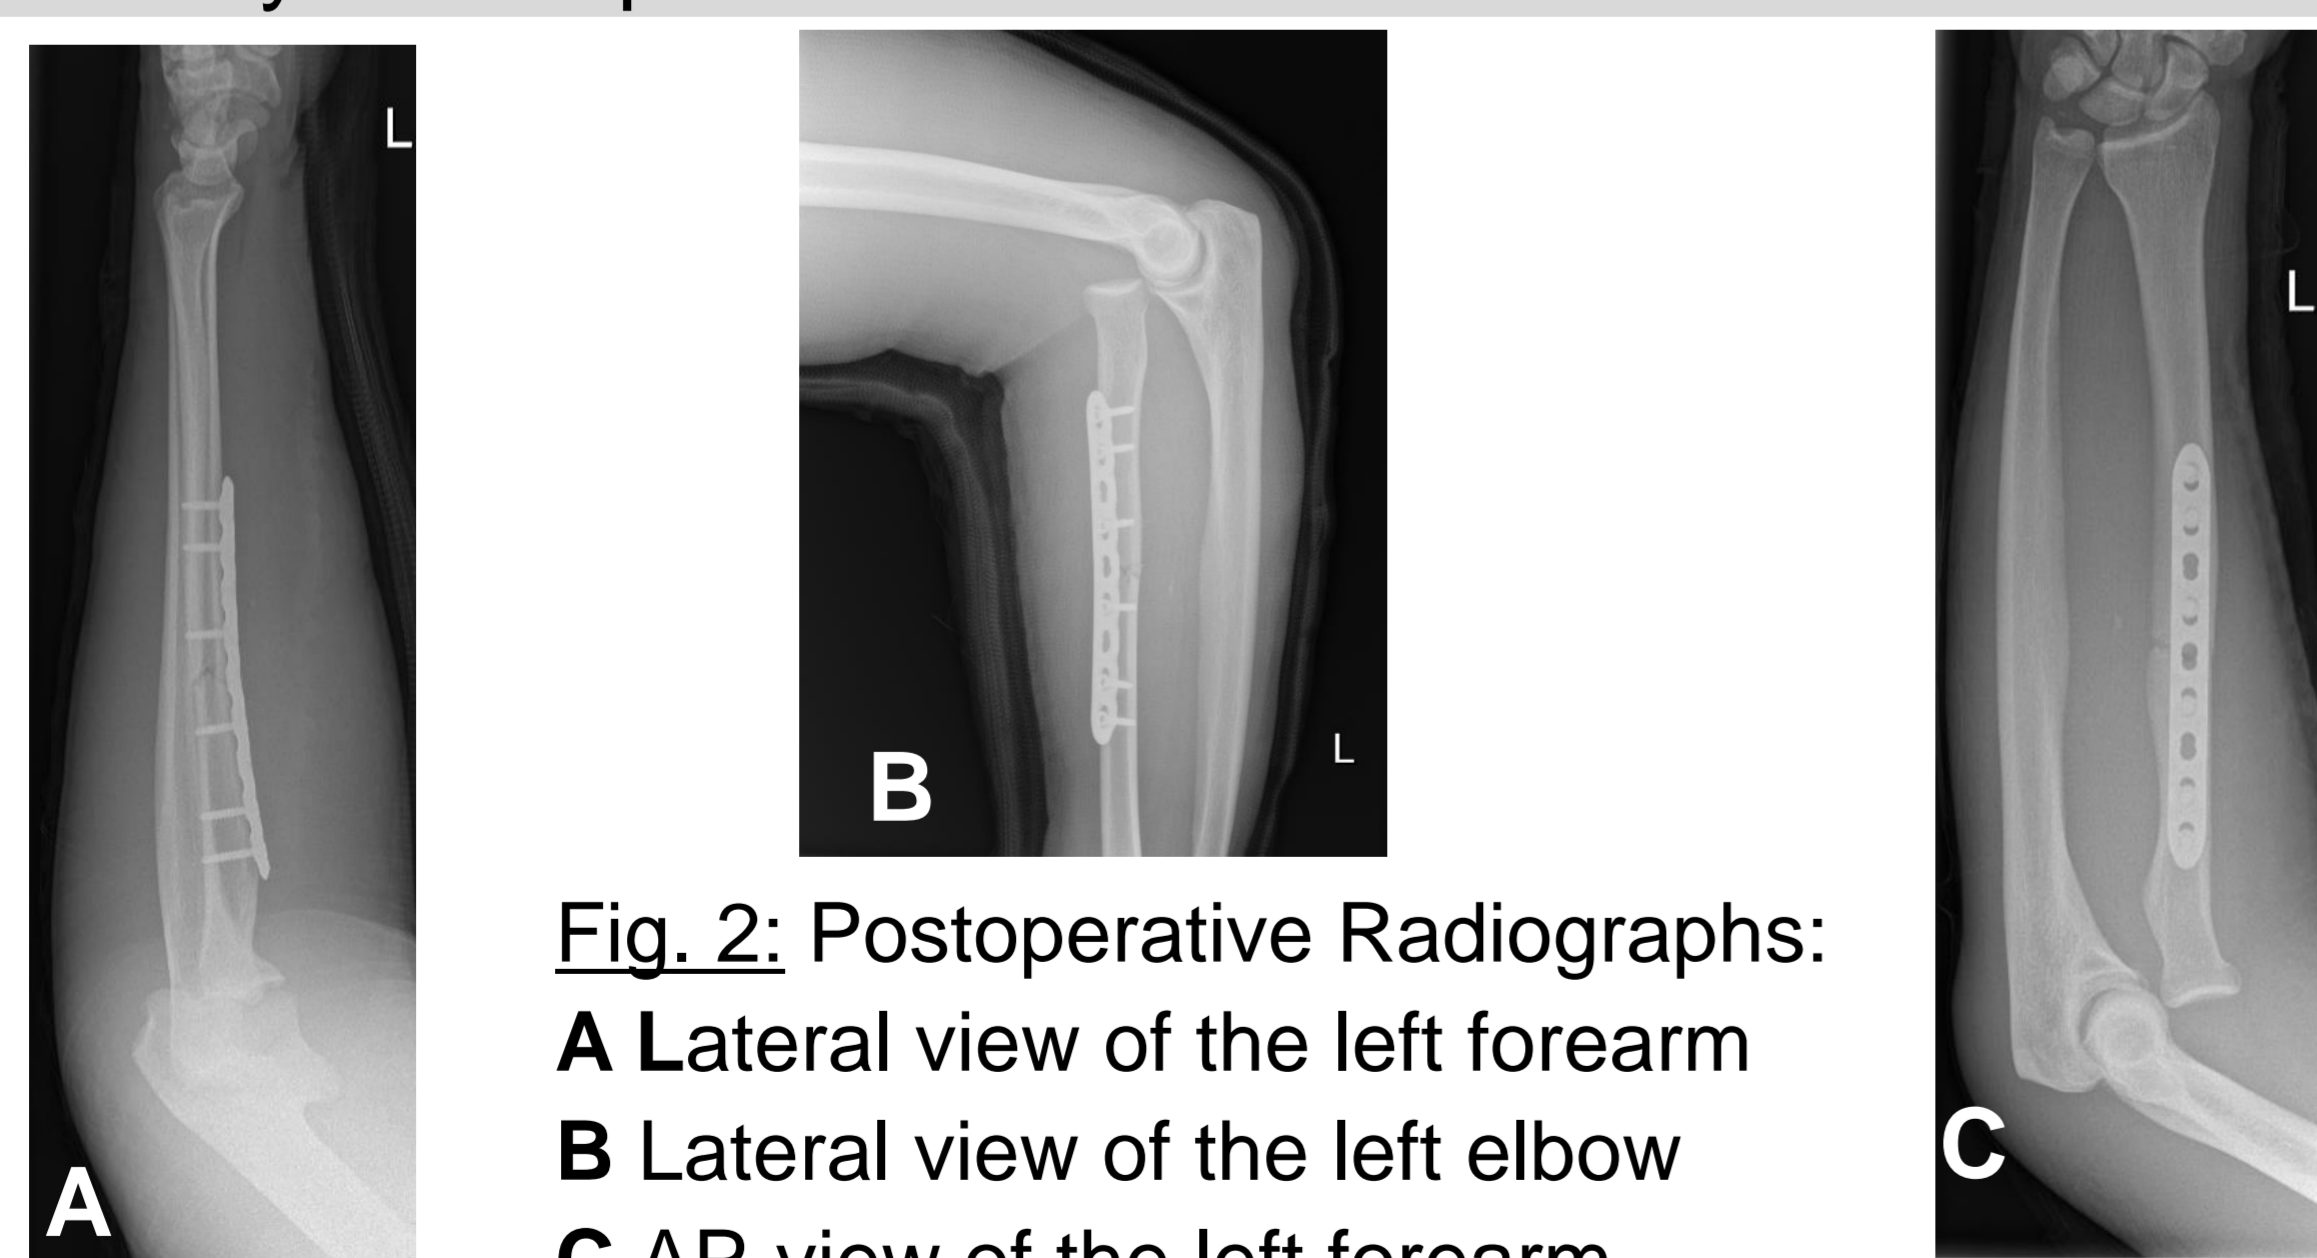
Postoperative Radiographs:
